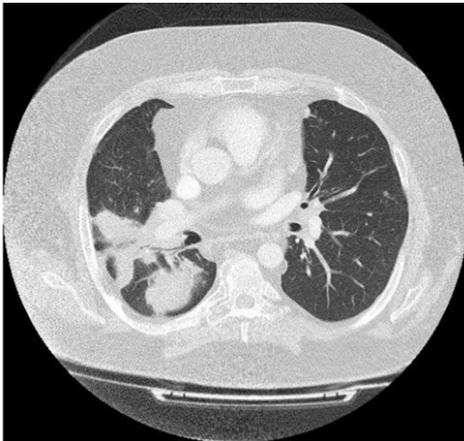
Chest CT scan showing consolidated and enlarged lesions. Image courtesy of Martin Hoenigl, MD.
